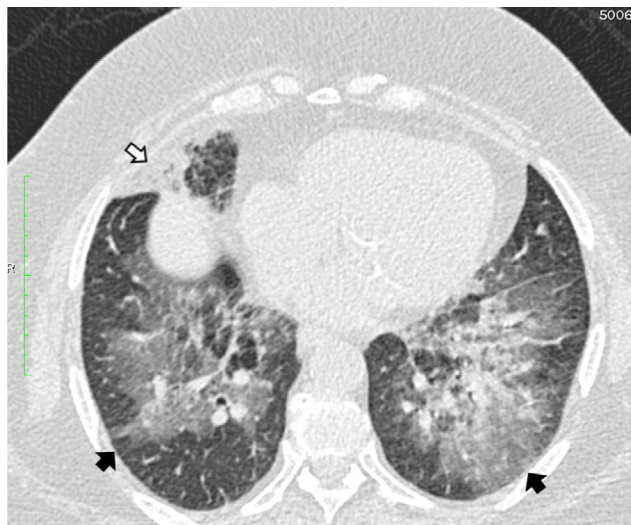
High resolution computed tomography scan of the chest shows peribronchial fat consolidation in middle lobe (white arrows). Extensive representation of GGO containing subtle reticulation (crazy paving) up to pleural spaces (black arrows) 8 months after discontinuing petroleum jelly (Vaseline) and steroid therapy (prolonged for 6 months).
